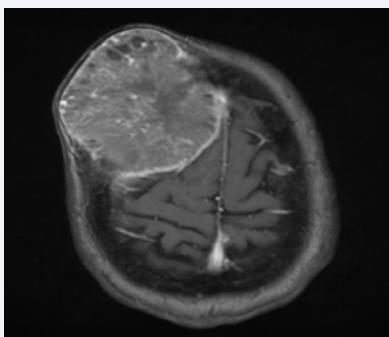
Axial brain MRI.
